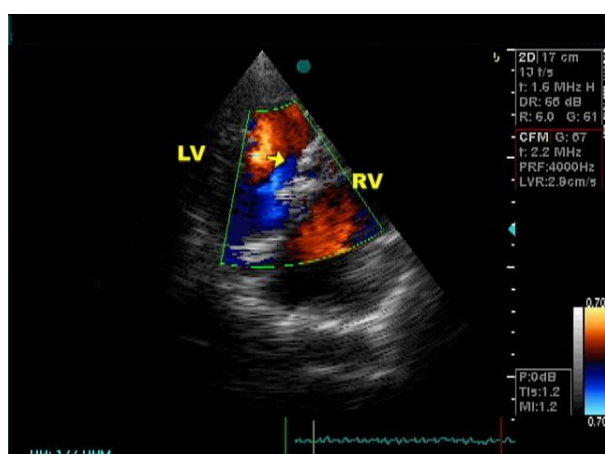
TTE with color doppler interrogation showing no flow through the cleft
